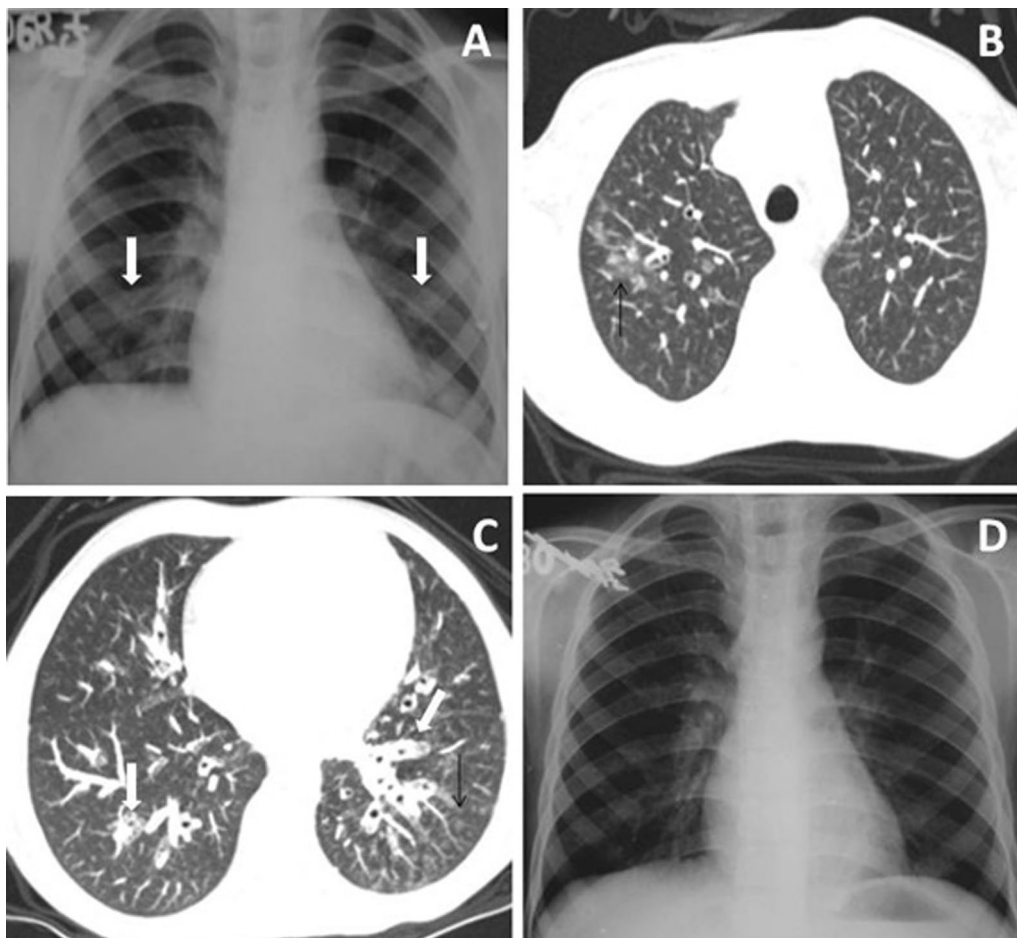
Bacterial Infection. A 10-year-old male, presented with cough and fever since last 2 days. Chest X-ray (PA view) reveals bilateral LZ haziness (arrows) (A). CT chest (axial view) shows subsegmental GGO in RUL (arrow) (B) and nodular air-space opacity in LLL (black arrow) along with bronchiectatic changes and peribronchial thickening in B/L LL (white arrows) (C). Sputum could not isolate any microorganism. CD4 count was 95 cells/cu.mm. Patient was given antibacterial antibiotics and improved clinically and radiologically (D) over a period of 4 weeks
